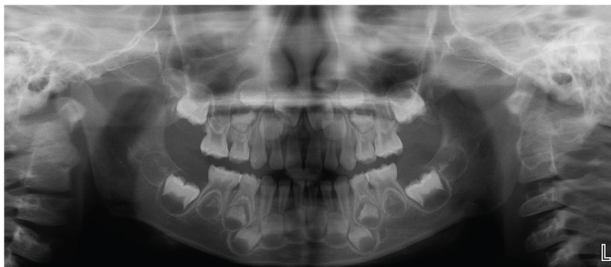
Postoperative panoramic radiograph showing the removal of the fractured needle.
